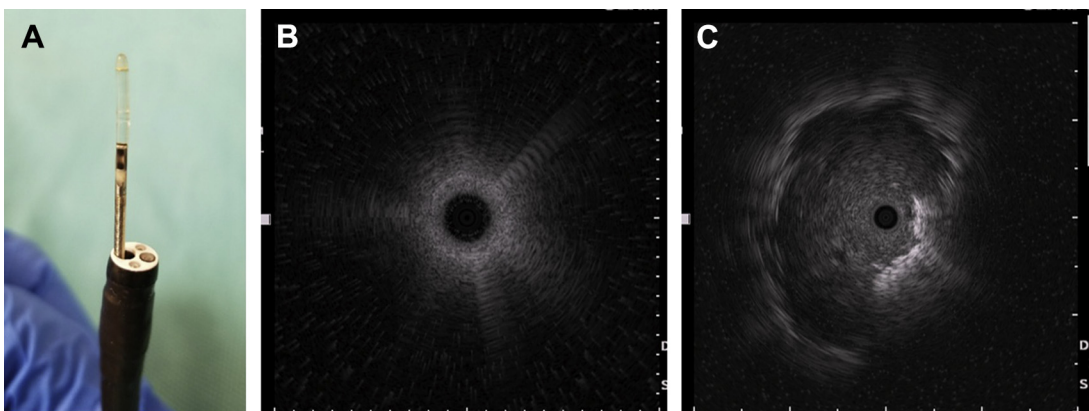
(A) Radial ultrasound probe. (B) RP-EBUS image of normal lung parenchyma. Note the “snowstorm” appearance. (C) RP-EBUS image of a solid nodule. Note the dark “solid” appearance of the nodule.
